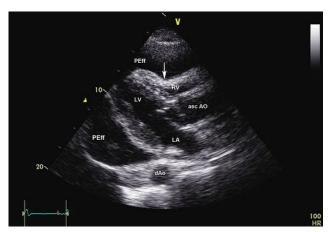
Cardiac tamponade: 2D parasternal long-axis view demonstrating a large circumferential, free-flowing PEff (Video A1). Diastolic collapse of the right ventricle is shown (*arrow*) consistent with cardiac tamponade.
